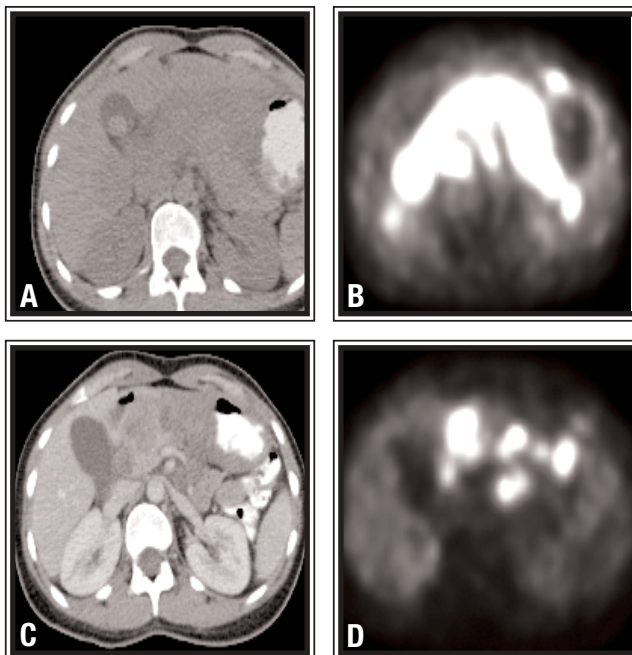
Large cell lymphoma. Abdominal mass is seen on CT (A) and PET (B). Following chemotherapy, the mass has shrunk (C), but PET shows activity (D), demonstrating that active lymphoma is still present.
